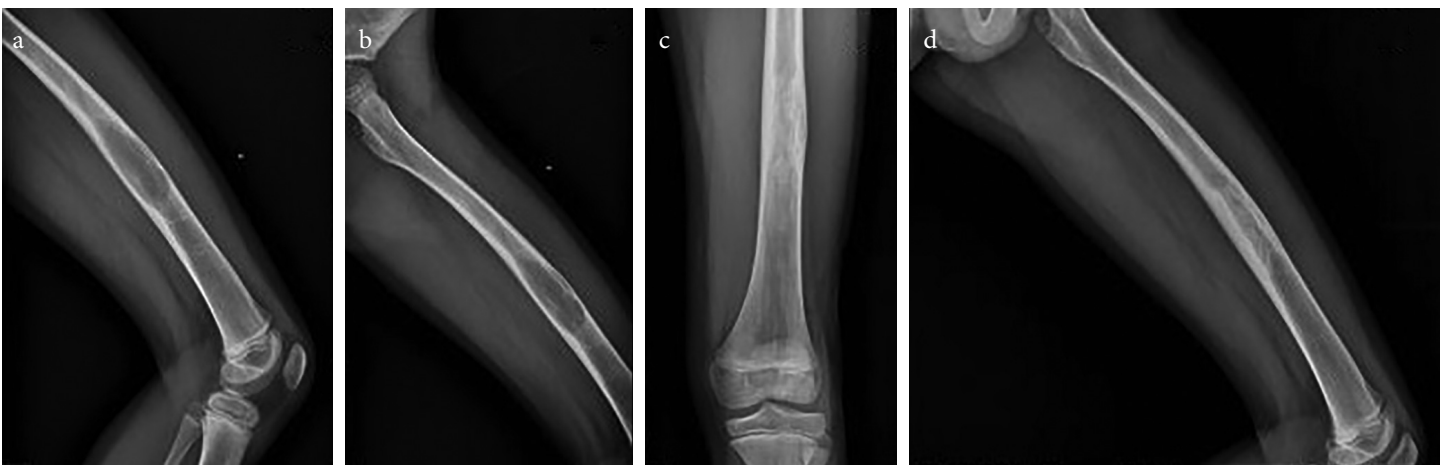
a-d. Diaphyseal femoral cyst treated with EDDBM+BMC injections; pre-operative (a, b) and post-operative x-rays (c, d) (success)
